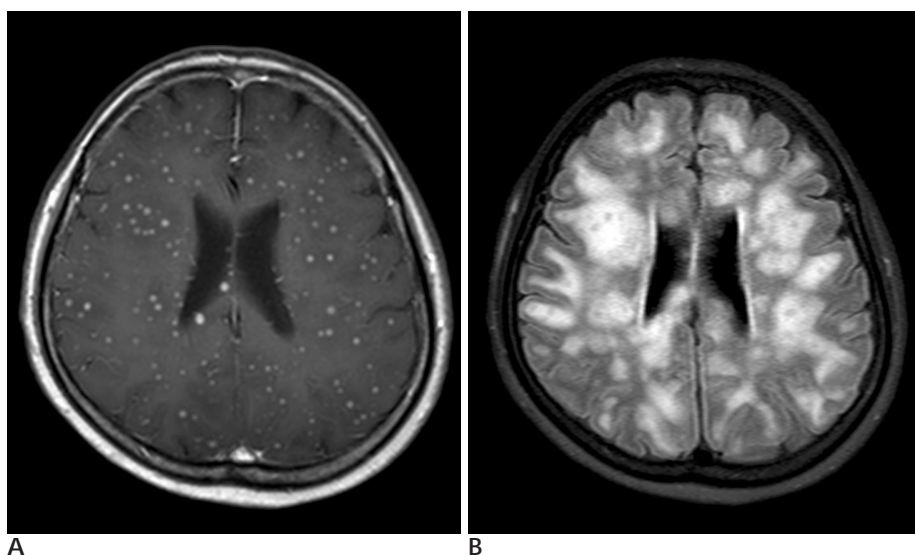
Contrast enhanced axial T1-weighted (A) and axial FLAIR (fluid attenuated inversion recovery) (B) brain MR scans.
